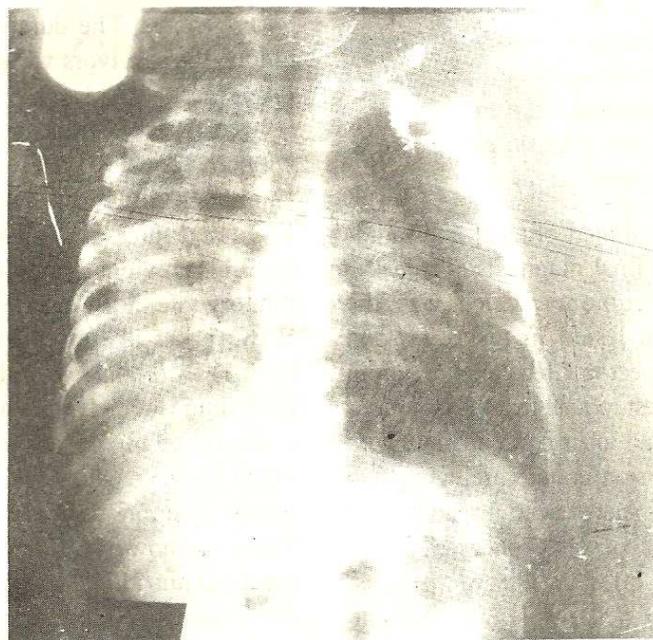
Chest radiograph of a 7-month old underweight girl, showing a right upper lobe consolidation with pneumatoceles and a bulging interlobar fissure. Cultures of blood and lung aspirate grew *Klebsiella* species.
